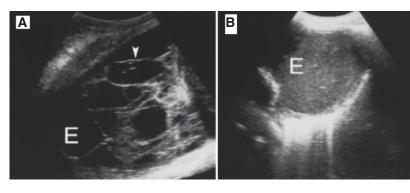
(A) Thoracic ultrasound showing complex pleural effusion along with septations (arrowhead). (B) Thoracic ultrasound showing homogeneously echogenic loculated effusion. E = effusion.
